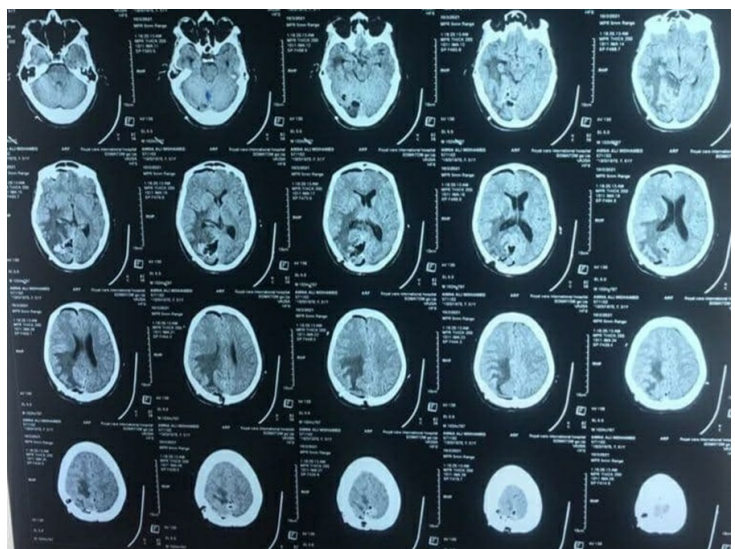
Plain CT brain done as follow up scan shows totally excision of both lesions.
